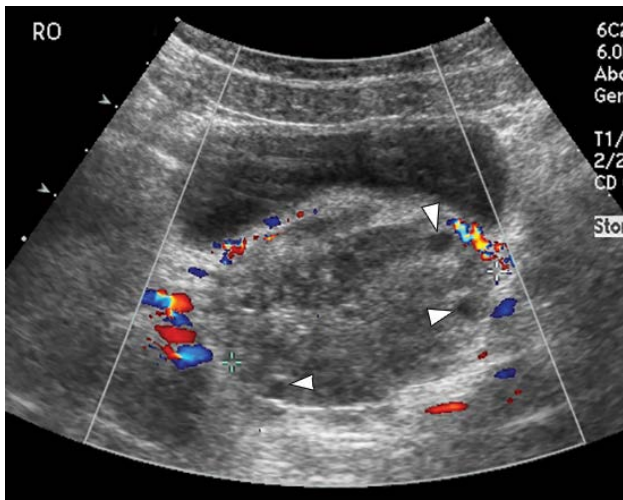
Ovarian torsion. Pelvis. Color Doppler ultrasound. Transverse plane. Region of the bladder. A solid avascular mass with peripheral follicles (arrowheads), characteristic of ovarian torsion (particularly in older children and adolescents), is seen posterior to the bladder.
